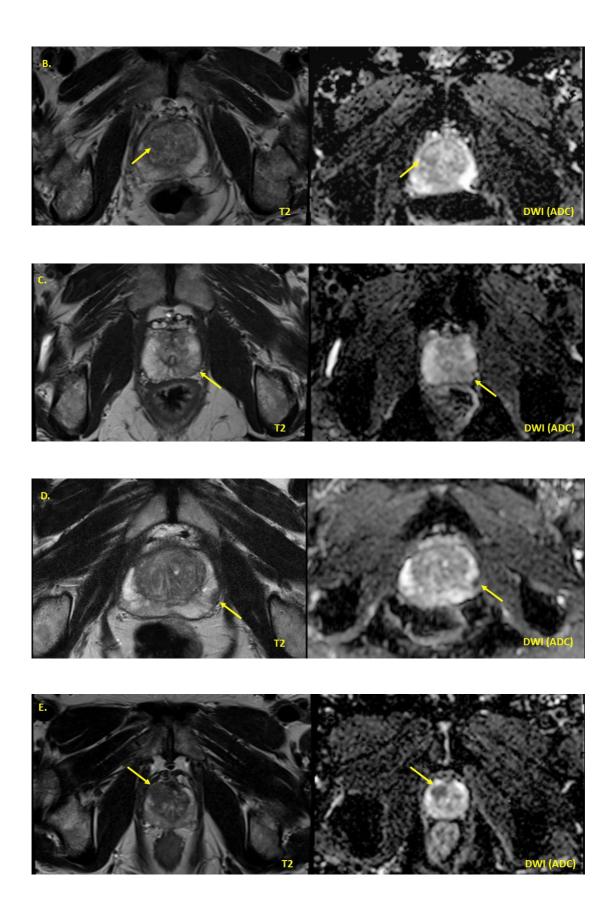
PIRADS v2.1 provides standardization of image interpretation of multiparametric Prostate MRI. A) T2-weighted and ADC map of PIRADS 1 demonstrating a peripheral and transition zone without evidence of low signal intensity or restricted diffusion. B) PIRADS 2 lesion of the right anterior transition zone. T2-weighted imaging demonstrates low signal intensity within a well-circumscribed nodule consistent with BPH and ADC map demonstrates mildly restricted diffusion. C) PIRADS 3 finding consistent with prostatitis. Regional/diffuse low signal intensity of the left mid peripheral zone which corresponds to mildly restricted diffusion. D) PIRADS 4 lesion of the Left mid posterior lateral peripheral zone. There is an 8mm region of low signal intensity and corresponding restricted diffusion. E) PIRADS 5 lesion of the right apical anterior transition zone. The lesion demonstrates a classic "erased charcoal" appearance with indistinct border. The 1.7cm lesion exhibits capsular bulge concerning for extracapsular extension and corresponds to severely restricted diffusion on the ADC map.
